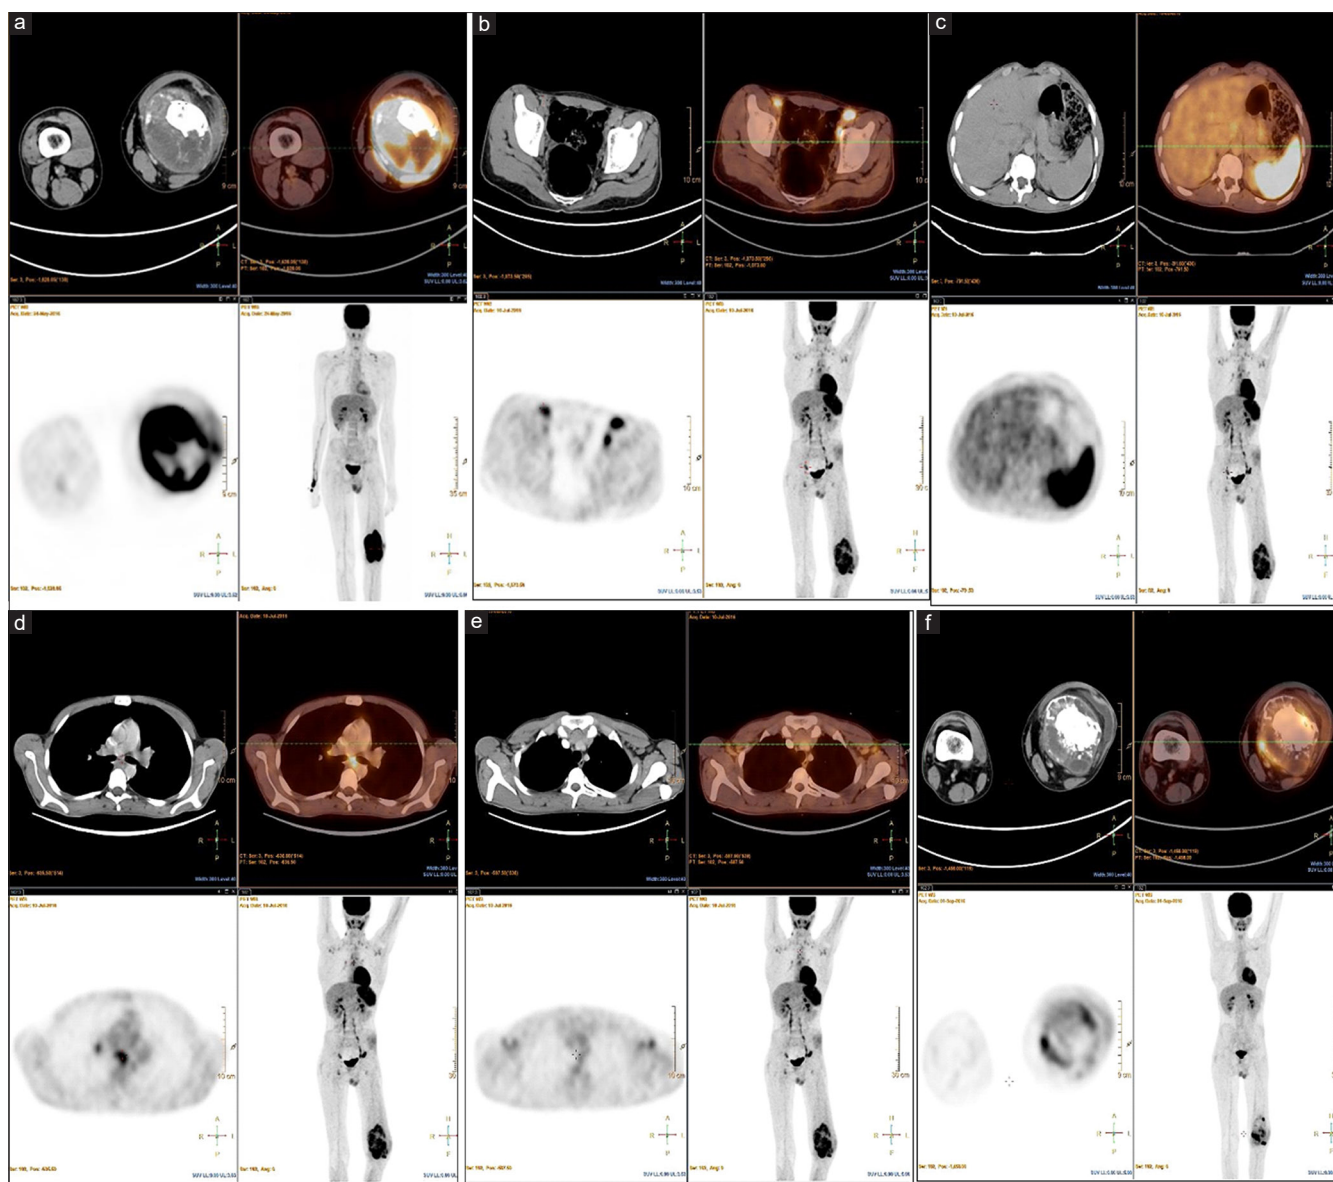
A 17-year-old male patient had left lower femur osteosarcoma. The first positron emission tomography/computed tomography detected solitary left external iliac lymph node with maximum standardized uptake value less than the reference hepatic activity. At second positron emission tomography/computed tomography, multiple fluorodeoxyglucose avid nodal lesions involving cervical, axillary, mediastinal, and abdominal–pelvic regions and diffuse splenic fluorodeoxyglucose uptake were detected, fine needle aspiration cytology from cervical lymph nodes revealed scanty lymphoid tissue with no evidence of atypical or malignant cells. At the third positron emission tomography/computed tomography, complete metabolic regression of all nodal lesions was noted. (a) Second positron emission tomography/computed tomography of the third case. (b) Second positron emission tomography/computed tomography showed fluorodeoxyglucose avid pelvic lymph nodes. (c) Second positron emission tomography/computed tomography showed diffuse splenic fluorodeoxyglucose FDG uptake. (d) Second positron emission tomography/computed tomography showed fluorodeoxyglucose avid mediastinal lymph nodes. (e) Second positron emission tomography/computed tomography showed fluorodeoxyglucose avid axillary lymph nodes. (f) Third positron emission tomography/computed tomography showed complete resolution of fluorodeoxyglucose lesions
